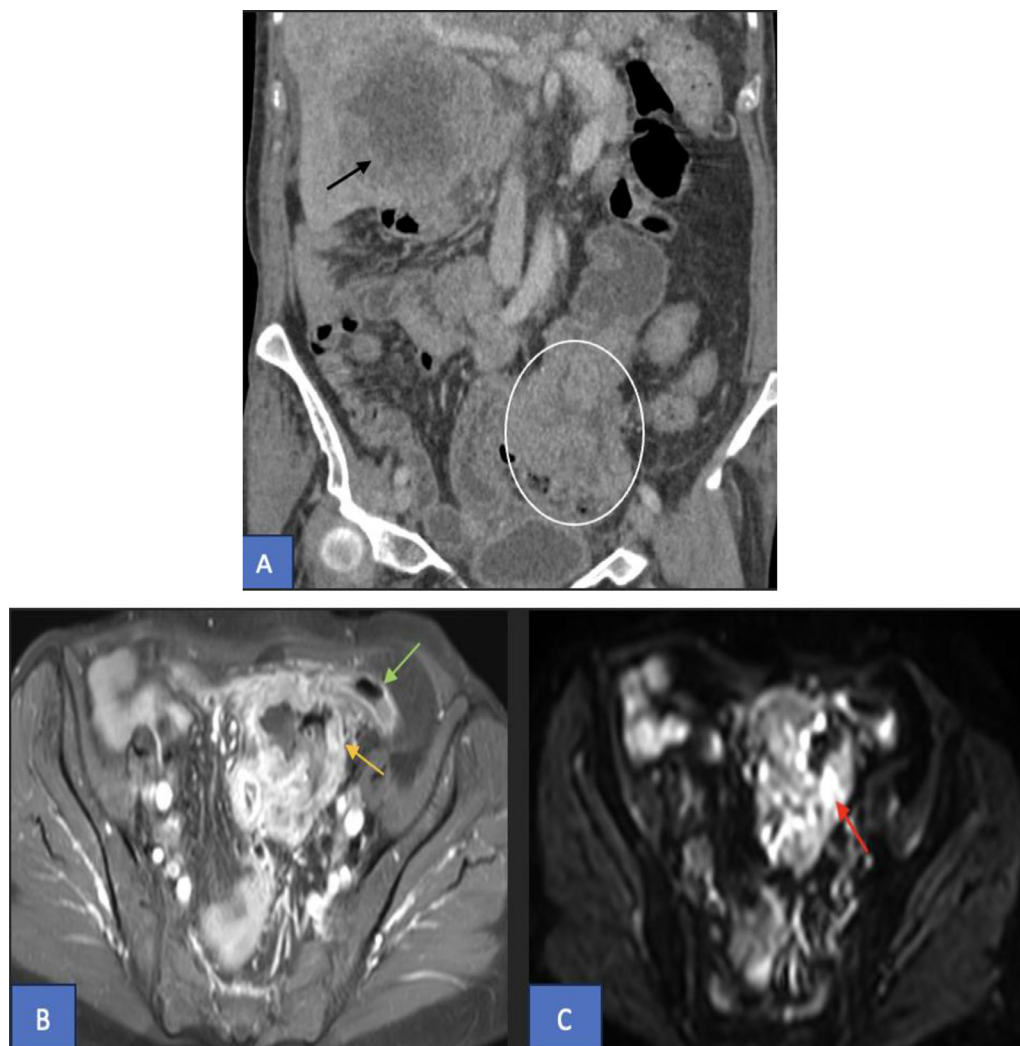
Coronal contrast-enhanced CT (A), with axial T1-weighted postcontrast MRI (B), and diffusion-weighted imaging (DWI) sequence (C) showing an irregular, circumferential thickening of the colonic wall on CT (white circle), accompanied by diffusion hyperintensity (red arrow) and gadolinium enhancement (yellow arrow). This thickening is localized at the pelvic cecal base near the sigmoid colon, with metastatic spread to the liver (black arrow). The thickening extends to the appendix, which appears infiltrated and swollen (green arrow).
